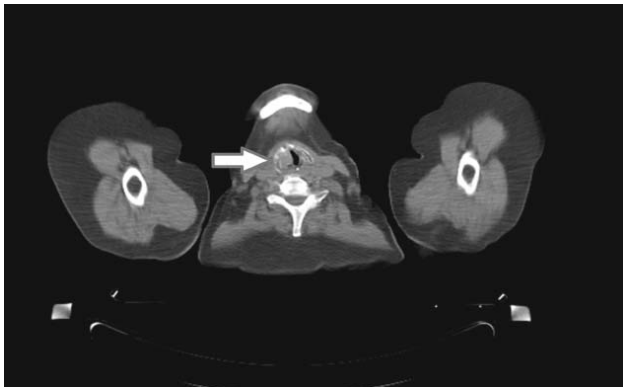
Axial CT demonstrate soft-tissue density in the right vocal cord
